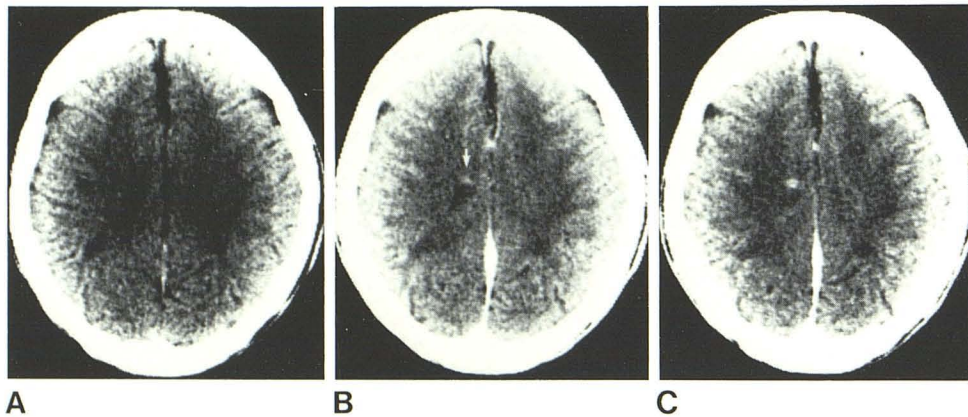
Questionable enhancement on standard CT, reinforced on high-volume delay scan. A, Noncontrast axial scan. Low-density lesions in both central semiovale. B, Standard contrast scan. Small area of enhancement difficult to differentiate from cortical vessel (arrow). C, Definitive enhancing plaque in right centrum semiovale with HVD.
